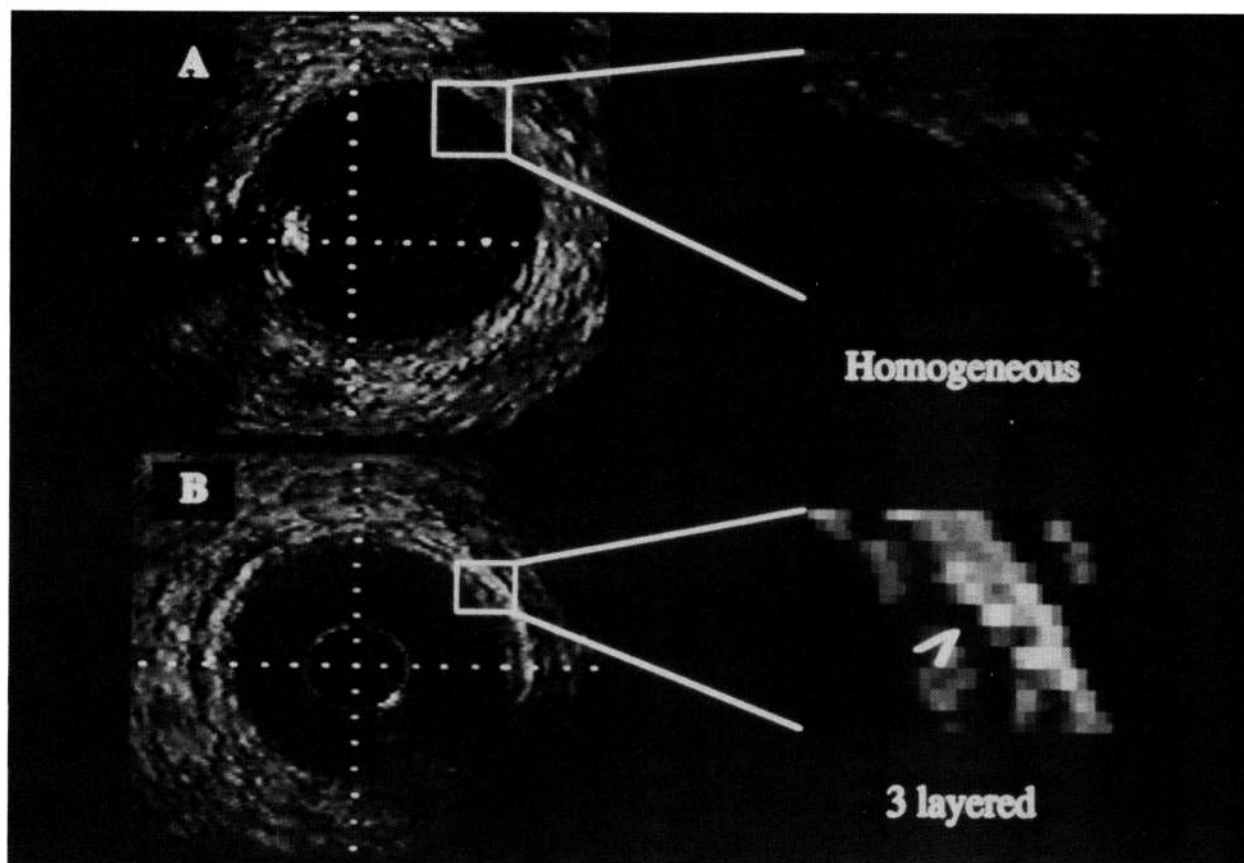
Panel A: Intravascular ultrasound image from the left anterior descending coronary artery of a patient with a 17-year-old donor heart. The dark black circle in the center of the image is the catheter. The perpendicular grid of tick marks are at 0.5-mm intervals. The circular vessel wall and surrounding tissue appear acoustically homogenous. The bright shadow at 9 o'clock on the edge of the catheter is an artifact caused by a mechanical strut and coronary guidewire. Panel B: Ultrasound image from the left anterior descending coronary artery from a 33-year-old donor showing thin but visible concentric three-layered appearance of the vessel wall. The white arrow indicates the hypoechoic medial layer.
